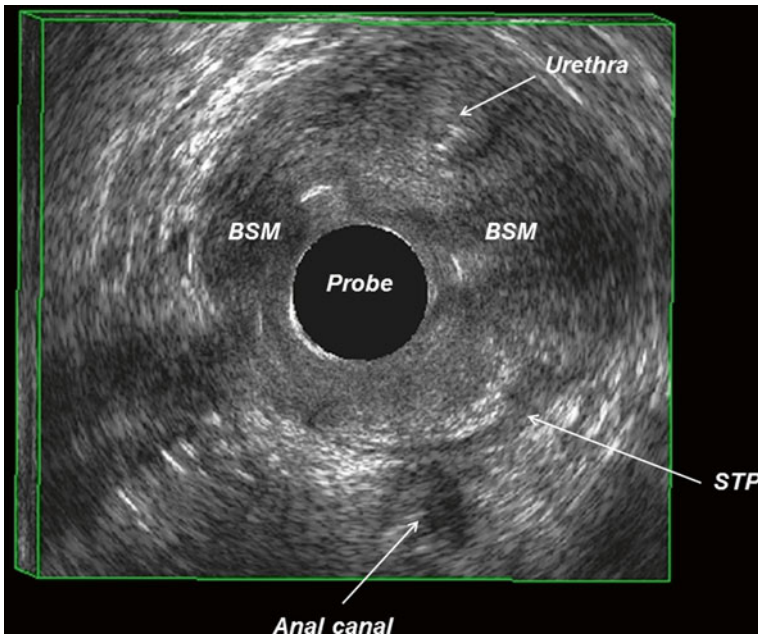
Perineal body damage due to obstetric trauma. 3D endovaginal ultrasound cannot visualize the perineal body in the central perineum neither the superficial transverse perinei (*STP*) muscle on the right side. *BSM* Bulbospongiosus muscle
